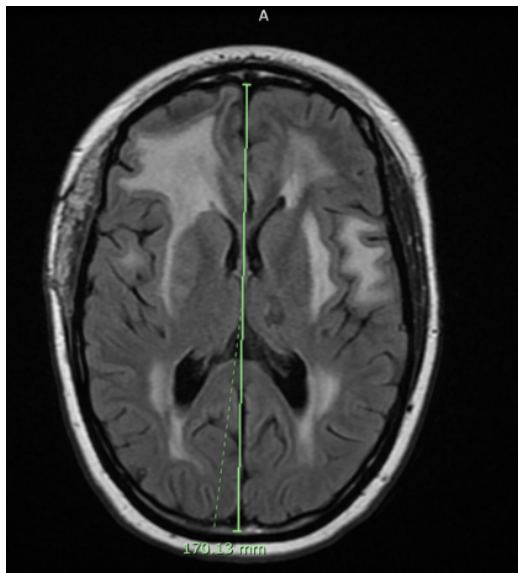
MRI brain with post-surgical changes and near resolution of previously noted cysts
